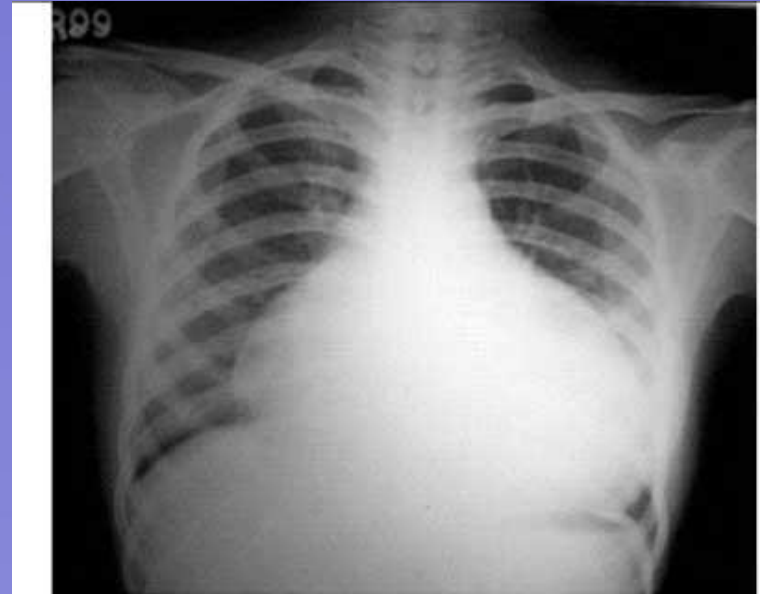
1 : Straight x-ray chest showing pericardial effusion (CT ratio is increased, cardiophrenic angles are acute, pulmonary vessels are not engorged).
